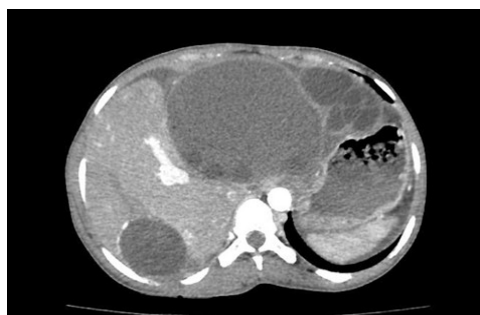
Showing CT axial image in arterial phase with multiple well-defined, round to oval cystic lesions with thin hyperdense internal septae within a cyst.
